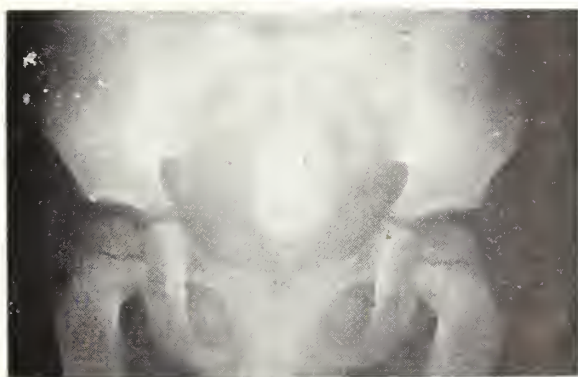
(a) Iban child having had bladder stone removed; (b) x-ray appearance of bladder stone.
